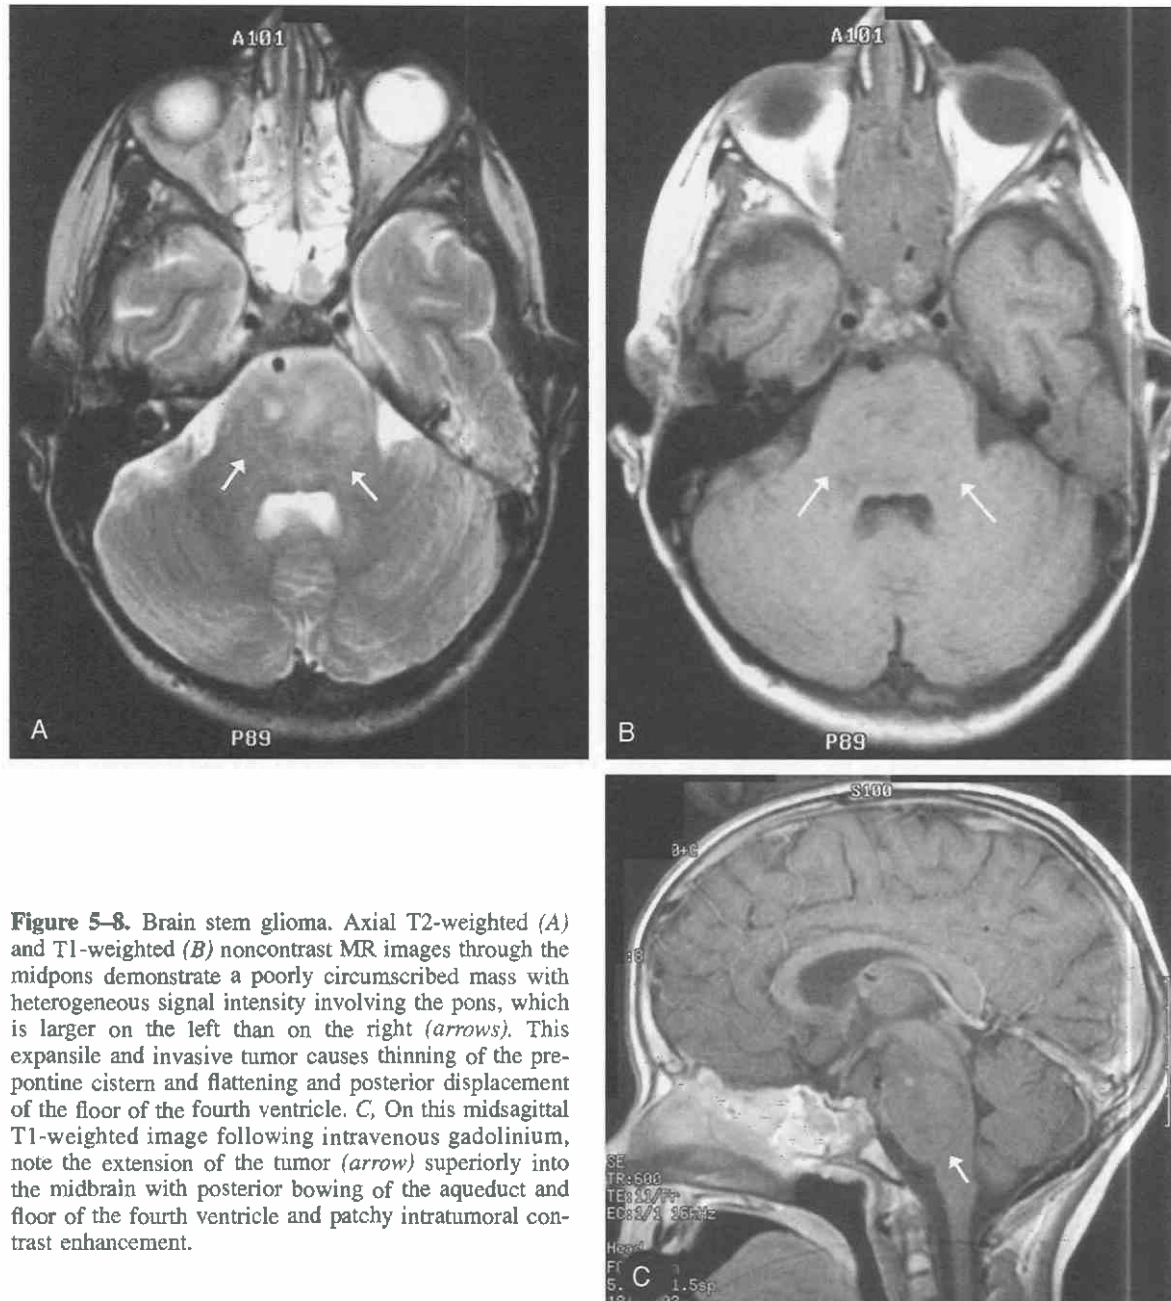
Brain stem glioma. Axial T2-weighted (A) and T1-weighted (B) noncontrast MR images through the midpons demonstrate a poorly circumscribed mass with heterogeneous signal intensity involving the pons, which is larger on the left than on the right (arrows). This expansile and invasive tumor causes thinning of the prepontine cistern and flattening and posterior displacement of the floor of the fourth ventricle. C, On this midsagittal T1-weighted image following intravenous gadolinium, note the extension of the tumor (arrow) superiorly into the midbrain with posterior bowing of the aqueduct and floor of the fourth ventricle and patchy intratumoral contrast enhancement.
